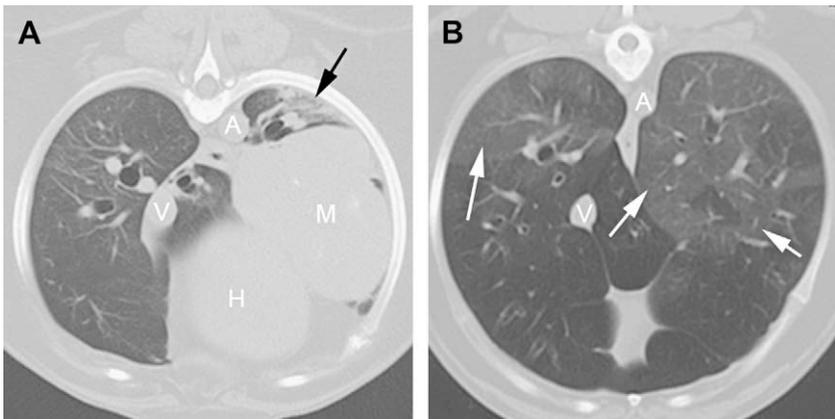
Thoracic CT Scans of a 14-year-old, neutered female Cocker spaniel (A) and a 3-year-old, neutered female West Highland terrier (B). In A, note the atelectasis in the left-caudal lung lobe (*black arrow*)—this lung lobe is incompletely inflated and has an increased opacity that partially to completely obscures pulmonary blood vessels. Immediately ventral to this lung lobe there is a lung mass (M). In this situation, the abnormal lung is consolidated, because it is fully inflated, and the increased opacity completely obscures the bronchovascular margins. When atelectasis and consolidation occur concurrently within the lungs, it may be problematic, especially during radiography, to differentiate the conditions. In B, the left- and right-caudal lung lobes have ground-glass opacity, (*arrows*) because the lungs are fully inflated, and bronchovascular margins are only partially obscured. The aorta (A) and caudal vena cava (V) are identified.
